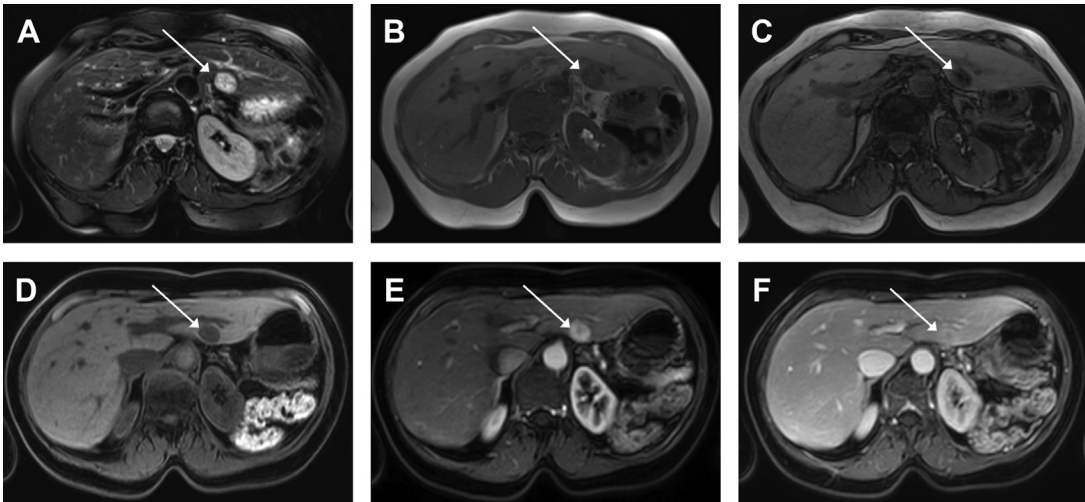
Example of hepatic angiomyolipoma. Rounded lesion demonstrating faint hyperintensity on fat-suppressed T2-weighted image (A), with dropout of signal in the opposed phase (B, C) in keeping with the internal fat. The lesion was hypointense on fat-suppressed T1-weighted imaging (D), with marked arterial hyperenhancement after injection of gadobenate dimeglumine (0.1 mg) (E) and no washout in the delayed phase (F). The diagnosis of hepatic angiomyolipoma was confirmed through biopsy.
